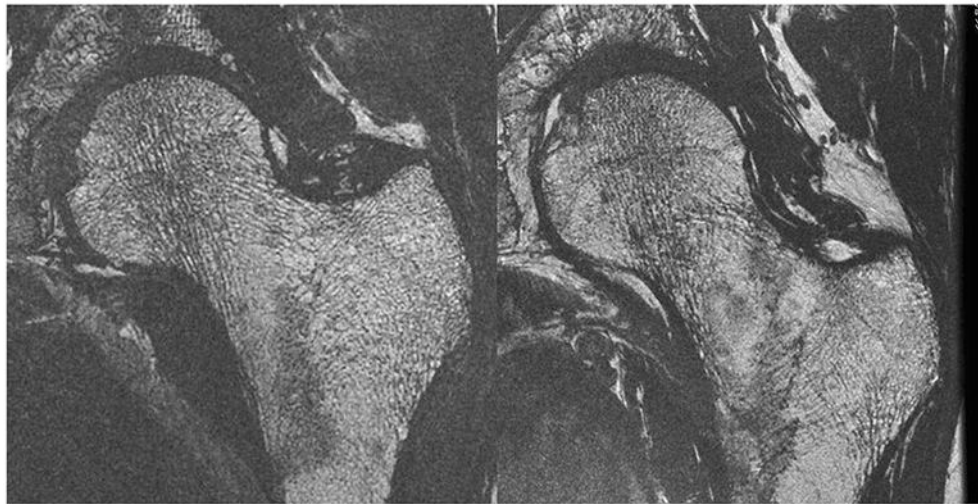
High-resolution MRI of the proximal femur in two postmenopausal women, one a healthy control (left) and one with osteoporosis and history of fragility fracture at a remote site (right). Courtesy of Roland Krug, PhD, UCSF
